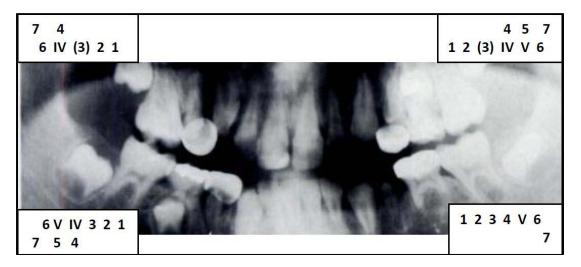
Boy aged 10 with acute lymphoblastic leukemia: dental formula and orthopantomogram.
